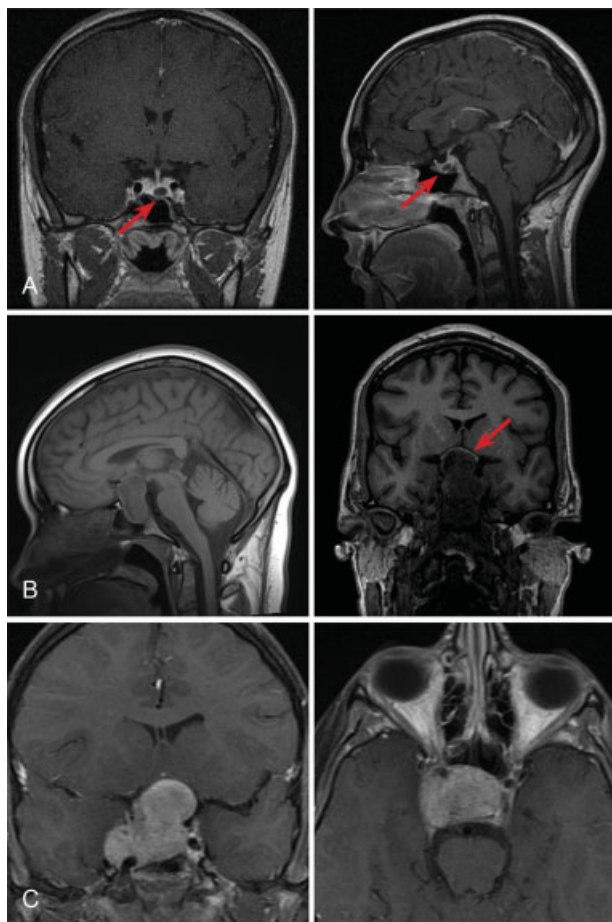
Gadolinium-enhanced T1-weighted MRI of the brain in the coronal and sagittal planes (A and B) demonstrates a hypo-enhancing eccentric left sellar masses (red arrows) surrounded by briskly enhancing normal hypophyseal tissue, characteristic of pituitary microadenoma. Pre-contrast sagittal T1-weighted and coronal MPRAGE images (B) demonstrate a large, well-circumscribed, sellar mass with surrounding benign bony remodeling, significant superior displacement of the optic chiasm (red arrow), and internal heterogeneity, consistent with a partially hemorrhagic pituitary macroadenoma. Gadolinium-enhanced T1-weighted coronal and axial images (C) demonstrate a large, vividly enhancing sellar mass, with invasion of the bilateral cavernous sinuses, encasement of the internal carotid arteries, and significant suprasellar and middle fossa extension, suggestive of an aggressive pituitary macroadenoma. MPRAGE, magnetization prepared rapid acquisition gradient echo; MRI, magnetic resonance imaging.
